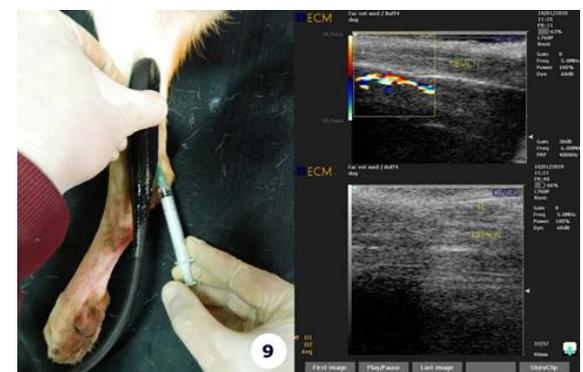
A Needle-Guided Ultrasonographic Technique showing the accurate safe approach for tibial nerve local anesthesia.
